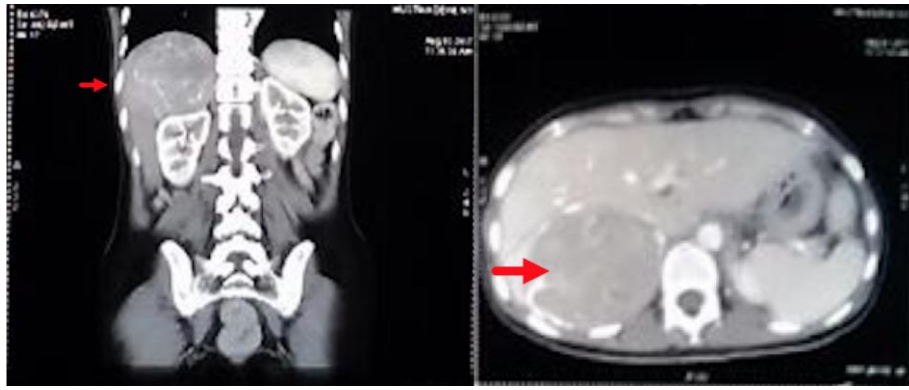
MSCT/CT scan abdomen with contrast
